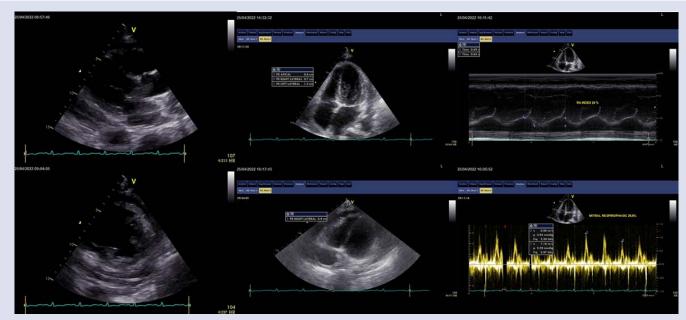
Echocardiographical findings of the patient after the intra-pericardial fibrinolytic.
